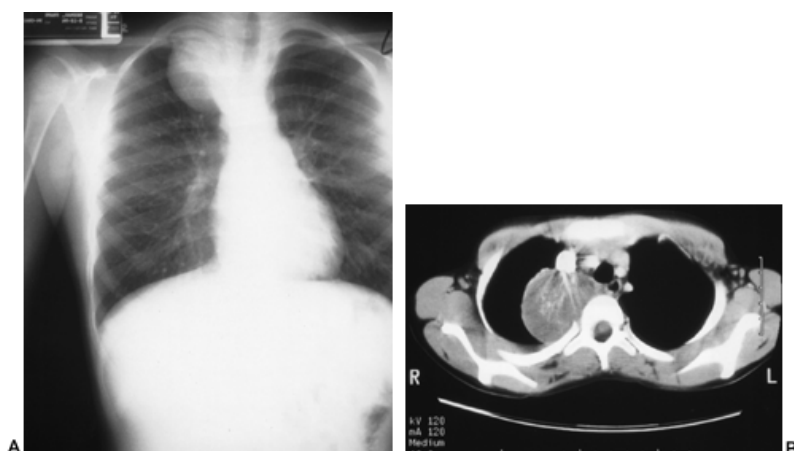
Neuroblastoma arising from the upper mediastinum. A: Chest radiograph. B: Computed tomography scan.
